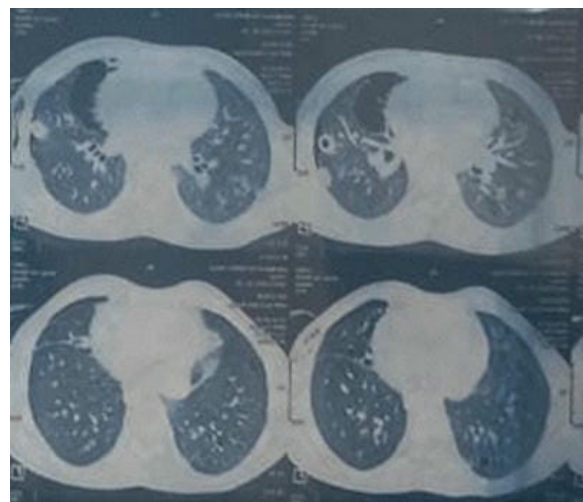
Chest computed tomography (CT) showed multiple cystic lesions in both lung fields, diffuse areas of mosaic attenuation with few areas of interlobular septal thickening. It also showed multiple variable-sized centrilobular nodules with irregular margins. Few of them show central margins.
